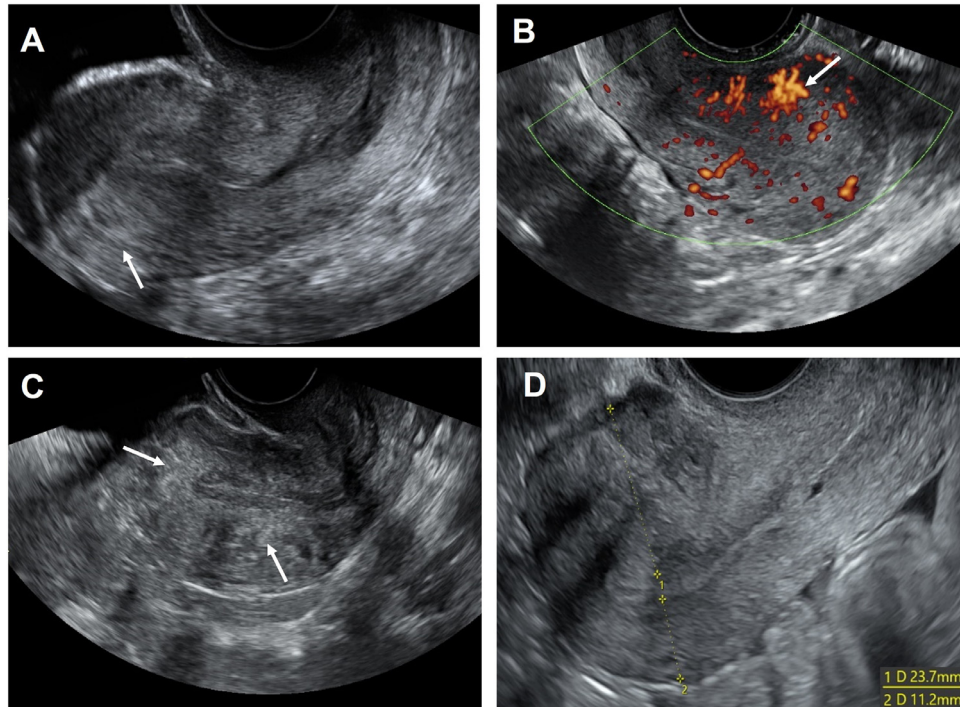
Transvaginal ultrasound images of adenomyosis. (A) Hyperechoic myometrial islands (arrow) (direct feature). (B) Translesional myometrial vascularization (arrow) demonstrated on colour Doppler scanning (indirect feature). (C) Diffuse hyperechoic myometrial islands (arrows) (direct feature). (D) Asymmetrical myometrial thickening, with the anterior and posterior myometrial wall thickness indicated by dotted yellow lines (indirect feature).
